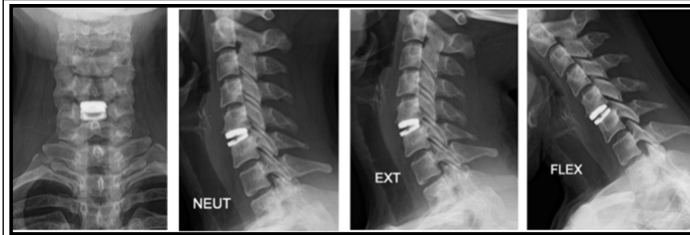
(a, b, c, d): Post-surgical anteroposterior, lateral neutral, and lateral dynamic radiographs of the cervical spine of a 38-year-old female with cervical radiculopathy show replacement of the cervical disc with a restored range of motion.
